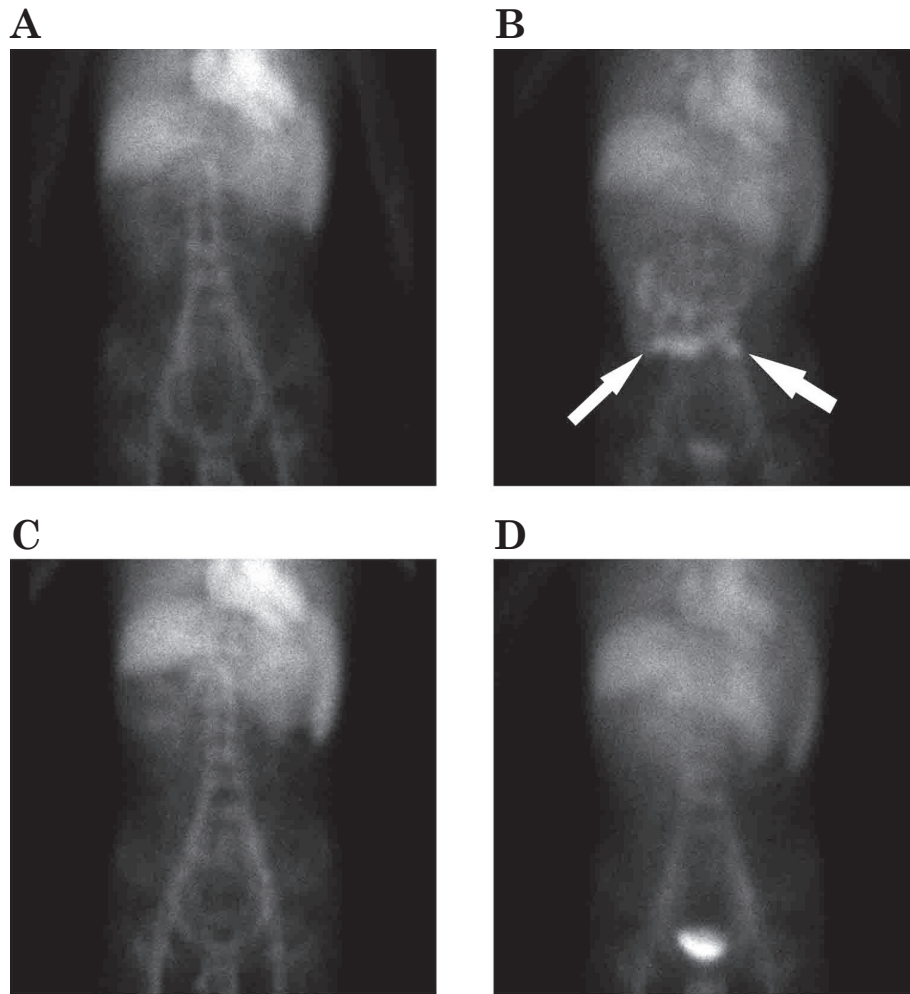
Results of ^{99m}Tc -human serum albumin scintigraphy on day 2 (A, 5 min after injection; B, 6 h after injection) and day 6 (C, 5 min after injection; D, 8 h after injection). White arrows indicate protein loss from the small intestine.
